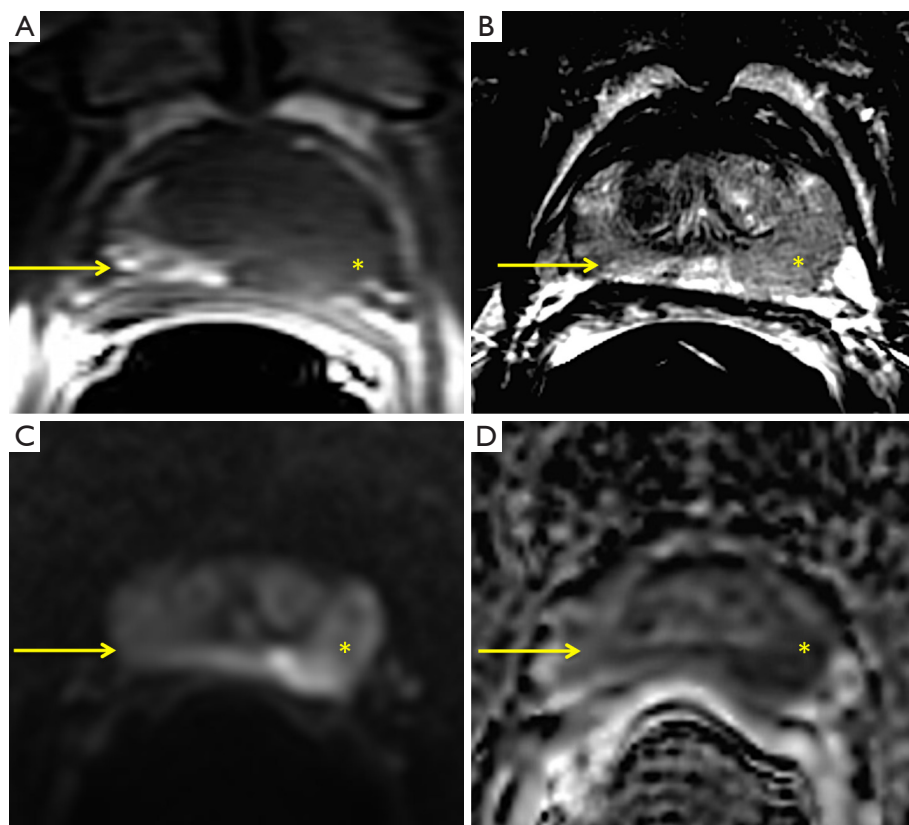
Axial T1WI (A) through the midgland of the prostate demonstrates a region of increased T1 signal in the right peripheral zone (arrow). On T2WI (B), this area has low signal intensity (B, arrow). This combination of high T1 and low T2 signal intensities is compatible with post biopsy hemorrhage. Note a second focus of low T2 signal intensity in the left peripheral zone (B, *). This second focus has low signal intensity on T1WI (A, *) and is, therefore, suspicious for prostate cancer. The likelihood of prostate cancer is further increased based on the results of DWI and ADC map, as the lesion demonstrates high signal on DWI (C, *) and low signal on ADC map (D, *). There is no reduced diffusion within the region of hemorrhage (C, arrow). T1WI, T1 weighted image; T2WI, T2-weighted image; DWI, diffusion-weighted MR imaging; ADC, apparent diffusion coefficient.
